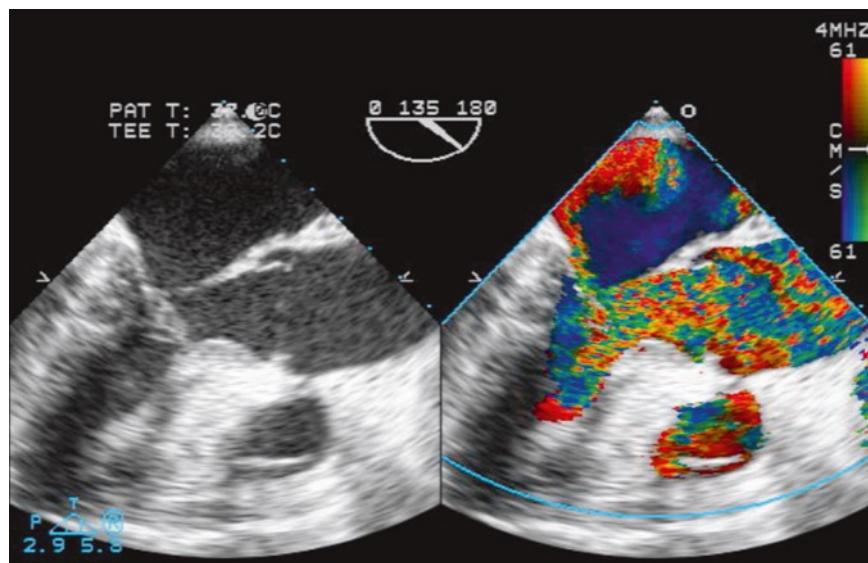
Case discussion. (a) Mid-esophageal four-chamber view, (b) zoom on mitral valve, (c) color Doppler of the mitral valve.
